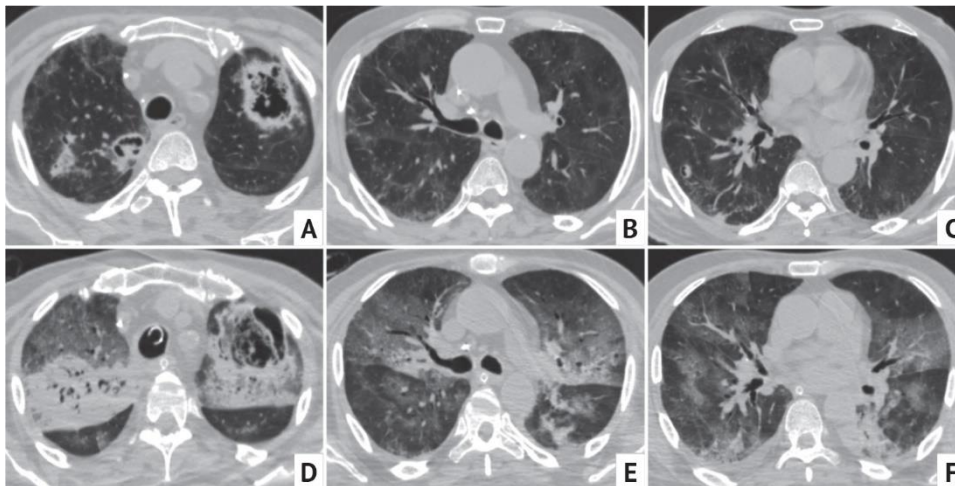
Axial chest CT images of a 68 y.o patient with poorly-controlled diabetes mellitus, after COVID-19 infection from 13.09.2020 (A–C) and from 21.09.2020 (D–F) at the corresponding levels. Embolic lung cavities (IE was diagnosed), negative dynamics. ARDS as a result of Klebsiella sepsis (multidrug resistant *Klebsiella pneumoniae*) — appearance of extensive ground-glass opacity (GGO) and consolidations
